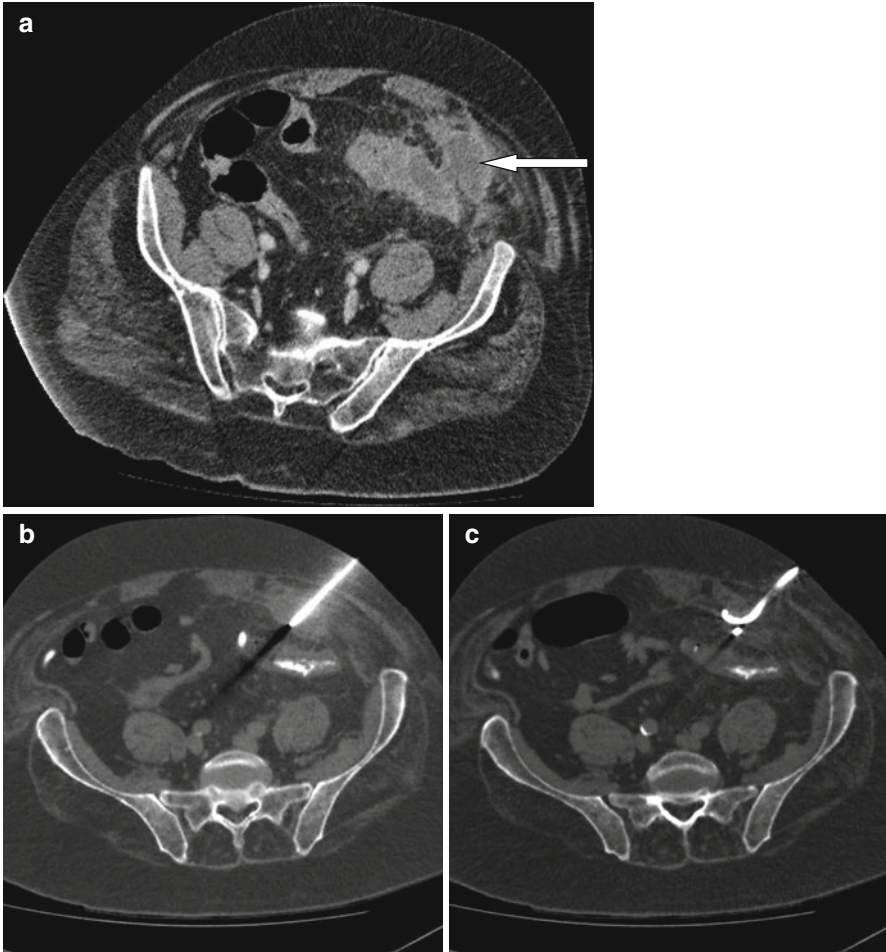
(a) Axial contrast enhanced CT image through the pelvis in a 75 year old male patient with left sided abdominal pain and sepsis demonstrates a grossly thick-walled sigmoid colon with an intramural abscess (*arrow*) tracking towards the anterior abdominal wall. The appearances were due to a diverticular abscess. Percutaneous drainage was subsequently performed. (b, c) Demonstrating percutaneous needle placement to gain access to the abscess cavity (b) and subsequent satisfactory final position of the drain coiled within the abscess (c) performed under CT guidance
